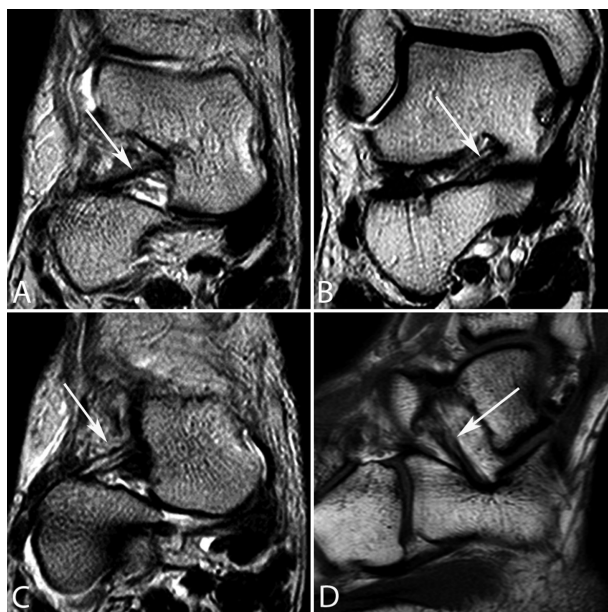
TSE T2-w coronal (A, B, C) and axial (D) MR images show normal findings of sinus tarsi ligaments; in particular, the cervical ligament (arrow in A and D), the Interosseous talocalcaneal ligament (arrow in B) and the extensor retinaculum (arrow in C)
